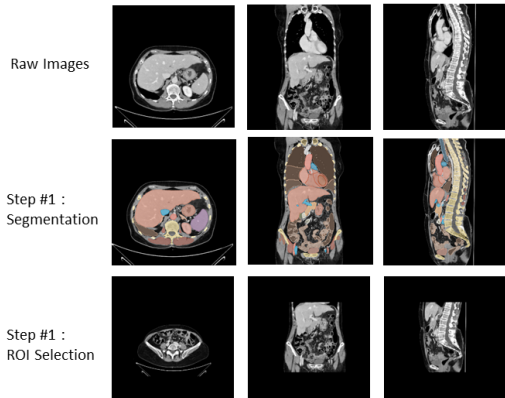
Preprocessing steps of TAP CT of patients with OC.
